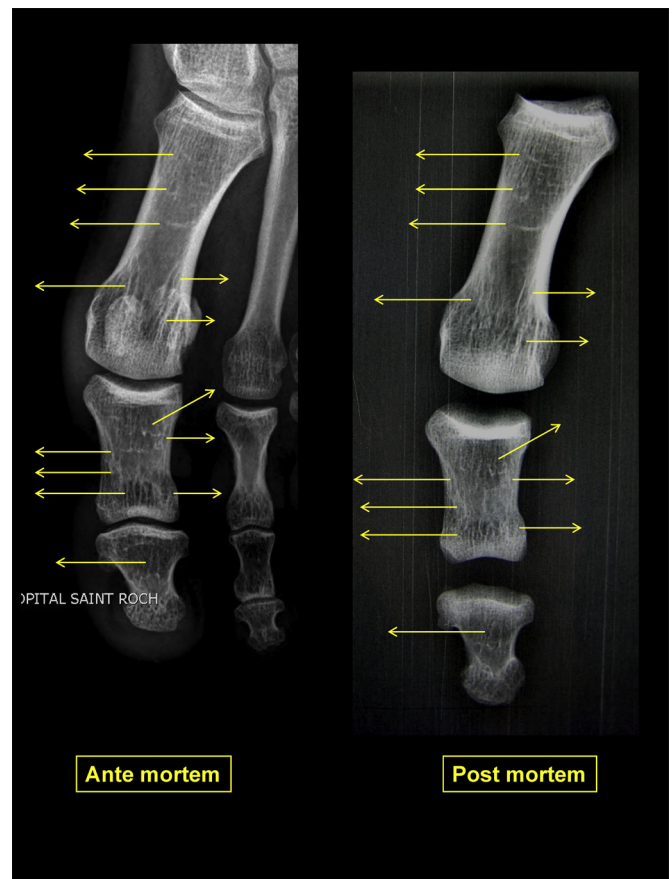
Trabecular comparison between the ante mortem available X-rays and the post mortem X-rays of the same bones, obtained after dissection in the autopsy room and anthropological preparation. Each arrow represents a specific and unique point of comparison. 13 obvious points of comparison are pointed out on the figure, but there were more than 30 useful points of comparison in each available bone of the foot.
